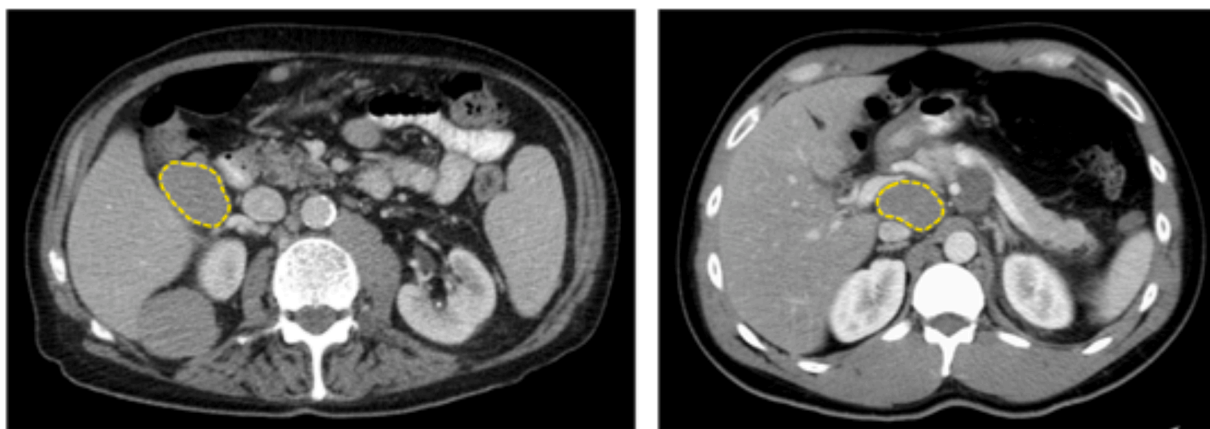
Comparison of 2 nodes from patients CT-scan. The left picture shows a responsive node (achieved a complete response) from a non-refractory patient and the right picture a refractory node (did not achieve a complete response) from a refractory patient. The two nodes have been successfully distinguished by the radiomics model despite a very similar visual appearance.
